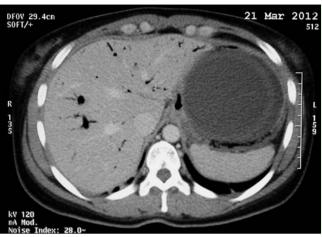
Contrastenhanced computed tomography (CT) scan of the abdomen showing extensive hepatic portal venous gas in an overweight 30-year-old woman with insulin resistance and a Spatz adjustable balloon system (ABS) inserted into the fundus and adjusted to 700 mL.
